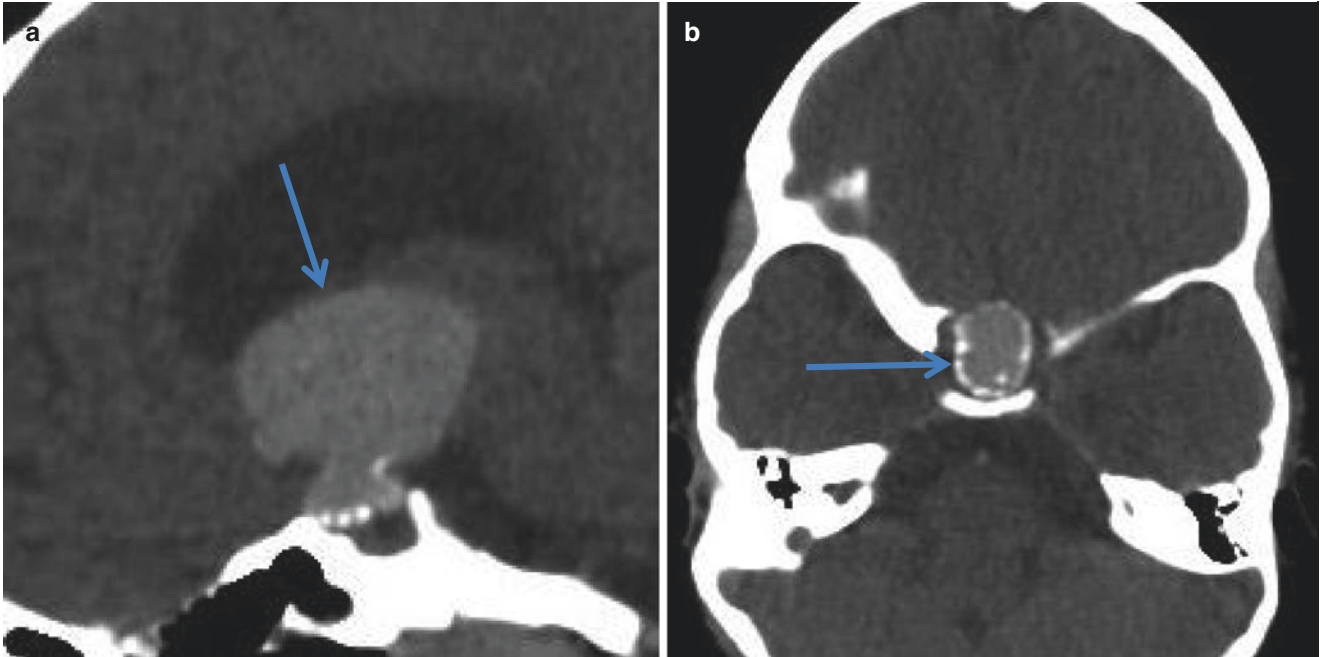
Craniopharyngioma. A 7-year-old boy presenting with headache and visual loss. (a, b) Post-contrast CT sagittal and coronal reformation. Suprasellar mass compressing the third ventricle, causing
